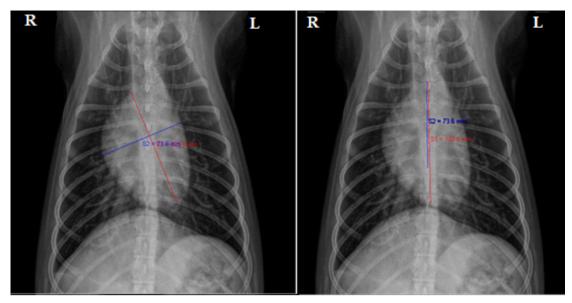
Vertebral Heart Size (VHS) measurement, using X-ray ventrodorsal projection. S1: long axis of the heart. S2: short axis of the heart. R: right. L: left. Source: Elaborated by the authors, according to Buchanan and Bücheler [5].
